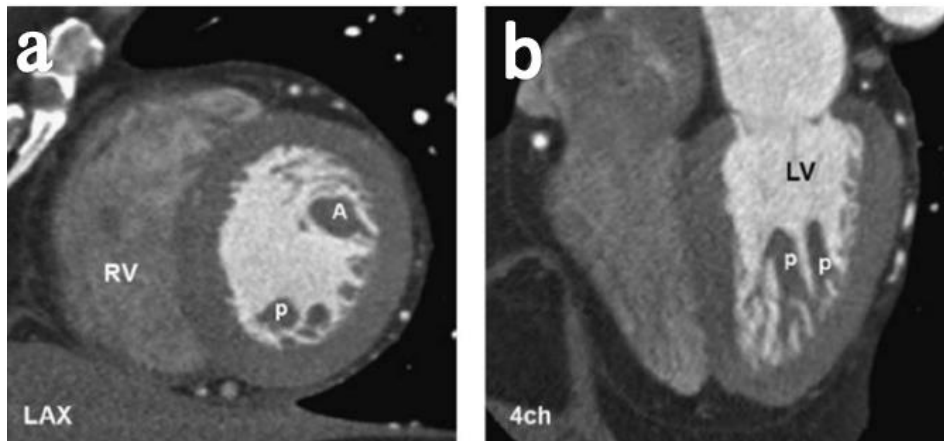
a) Short-axis and b) four-chamber CT views displays the anterior (A) and posterior (P) papillary muscles. The anterior one is larger and less tethered to the LV wall (*Quoted from Saremi and Sanchez-Quintana, 2011*).
